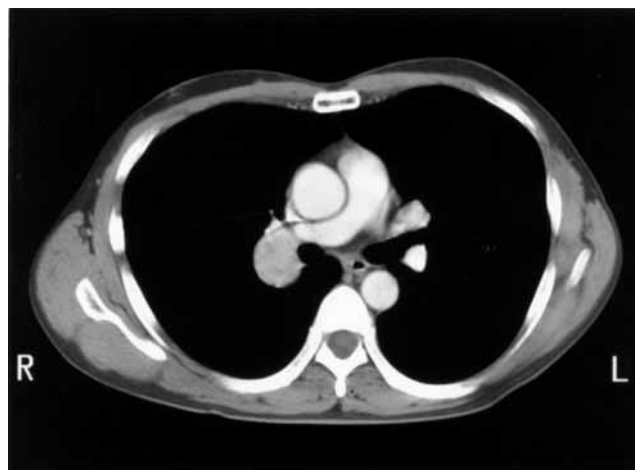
CT scan of the thorax showed a 2.5 cm clearly-demarcated mass at the bifurcation of the right upper lobe branch and the truncus intermedius.
